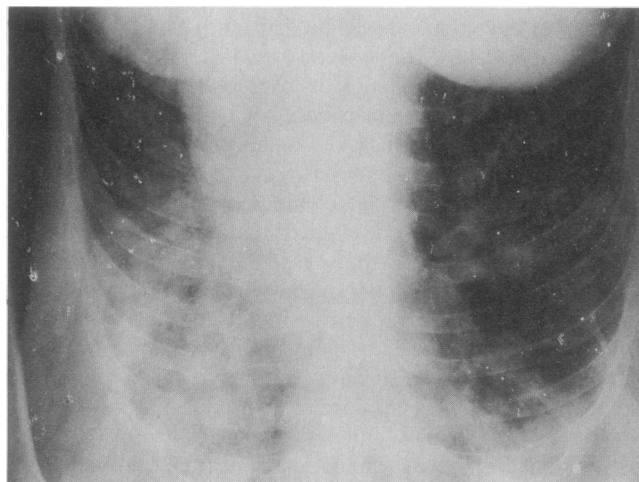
Roentgenogram of patient's chest taken just before open-lung biopsy, showing new diffuse alveolar and interstitial infiltrates.
